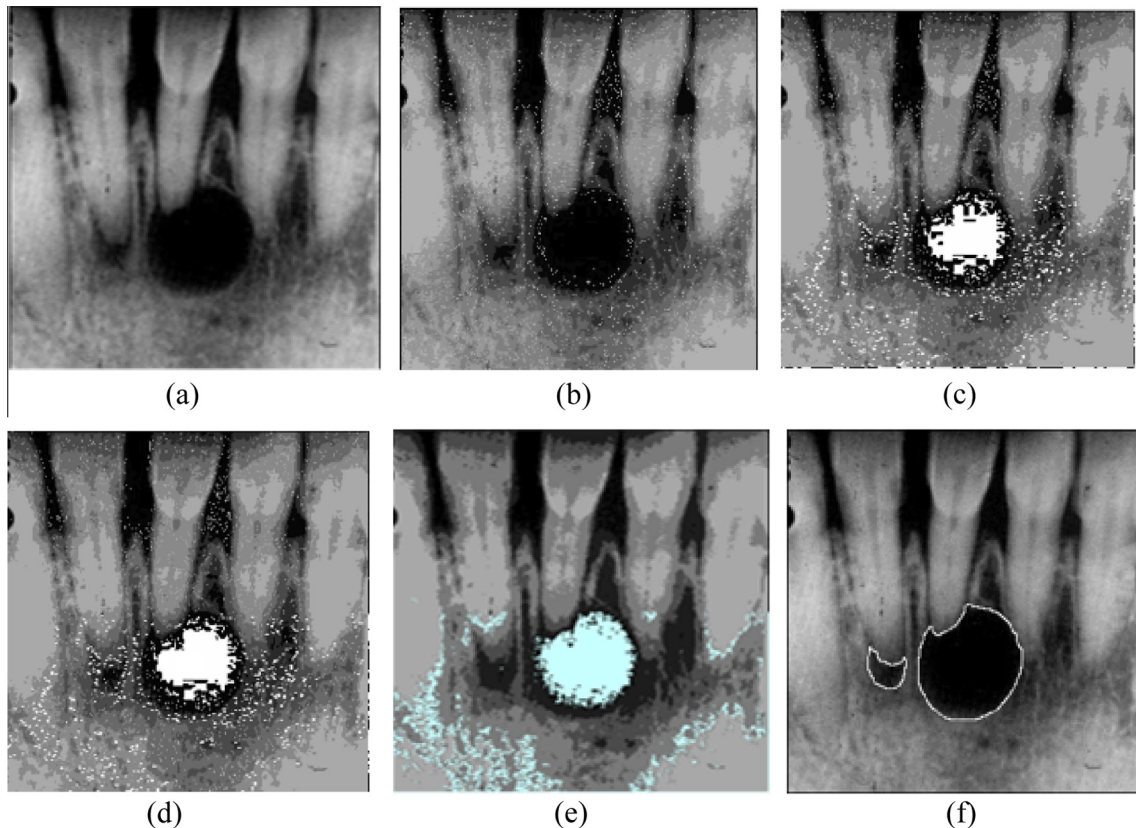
(a) Is the original abnormal real jaw's panoramic X-ray images (periapical-lateral and residual cyst), (b) segmented result acquired by FCM, (c) segmented result acquired by the ABCFCM, (d) segmented result acquired by the FAFCM, (e) segmented result acquired by the NFCM and (f) manual delineation by Oral Pathologist, respectively.
